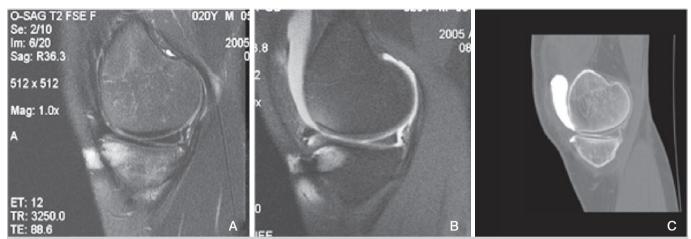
Knee MRI, Arhro-MRI and Arthro-CT after meniscal suture. See the hypersignal in T2 (left) and the penetration of the contrast medium (middle and right pictures).
